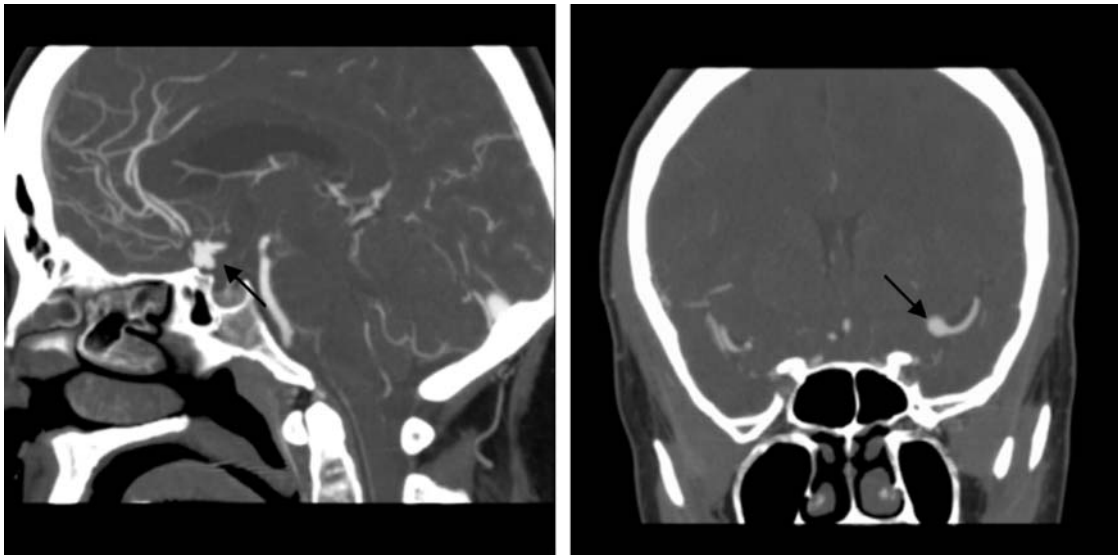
Examples of aneurysms found with CTA (arrows).
